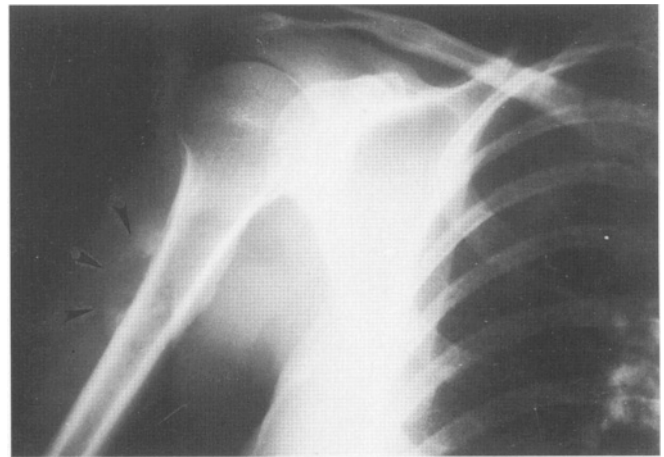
Periosteal osteosarcoma of the proximal humerus. Plain radiograph shows a typical "scooped-out" appearance of a cortical lesion (arrows). The center of the lesion has a lytic appearance because of its chondroblastic features. (Cancer: Principles & Practice of Oncology, 6th Edition, 2001; 39.2: 1891–1935)
